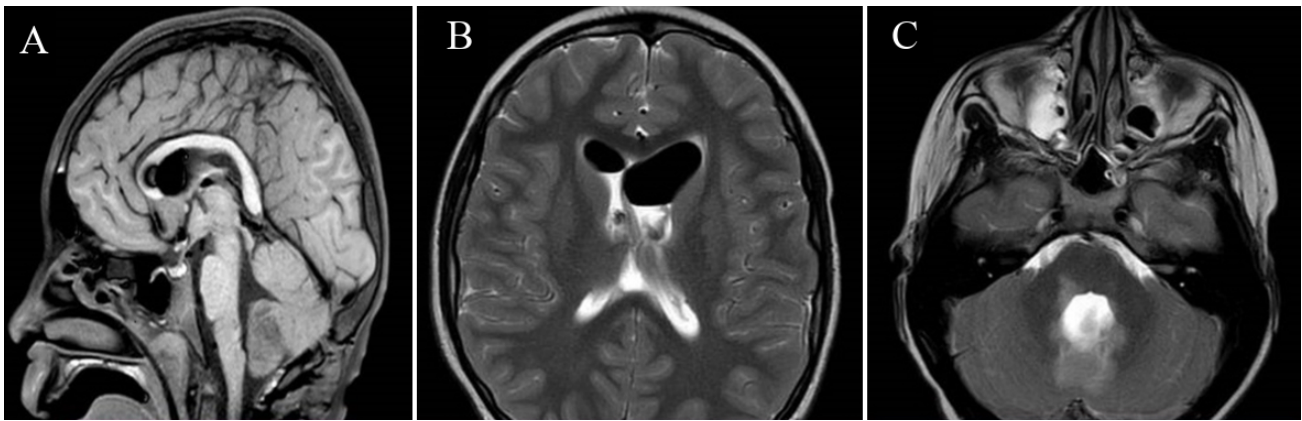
The brain MRI on the 1st day after microsurgical hematoma removal (IV ventricle)
